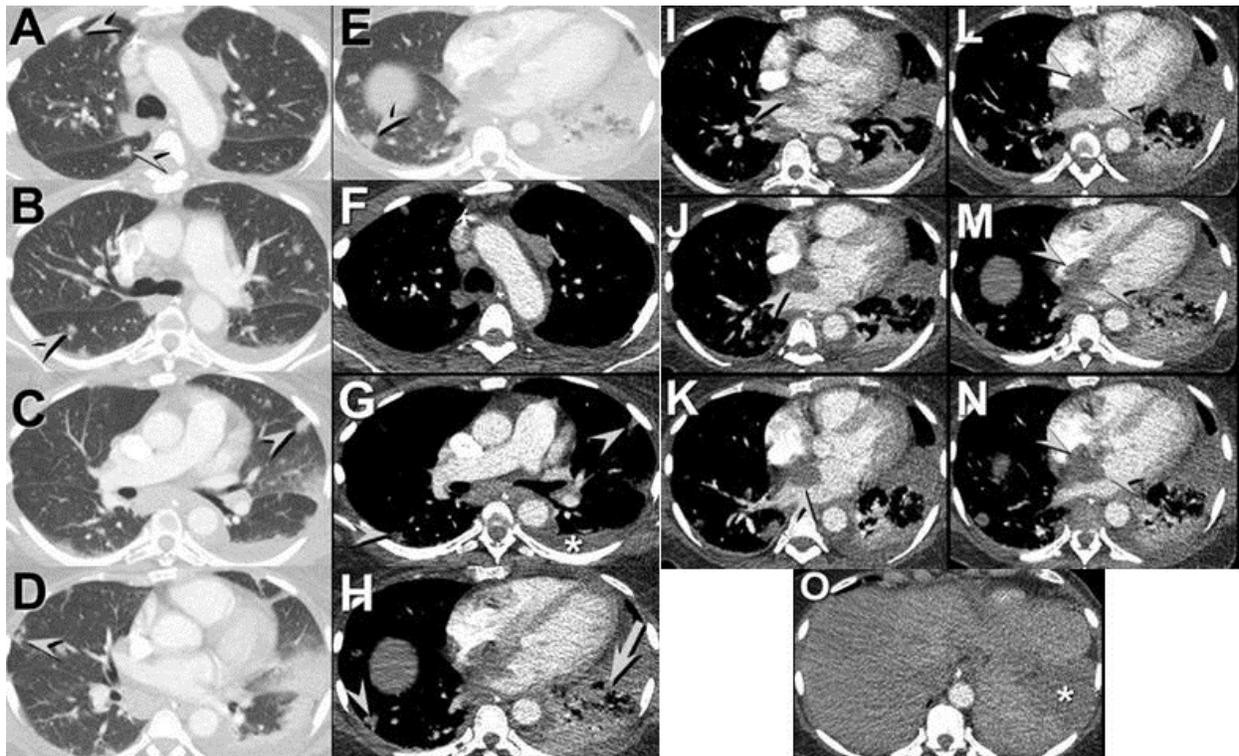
Panels A-H: Axial contrast-enhanced thoracic CT displayed in lung (A-E) and soft tissue (F-H) windows. Panels I-O: Caudally acquired axial contrast-enhanced thoracic CT images.
